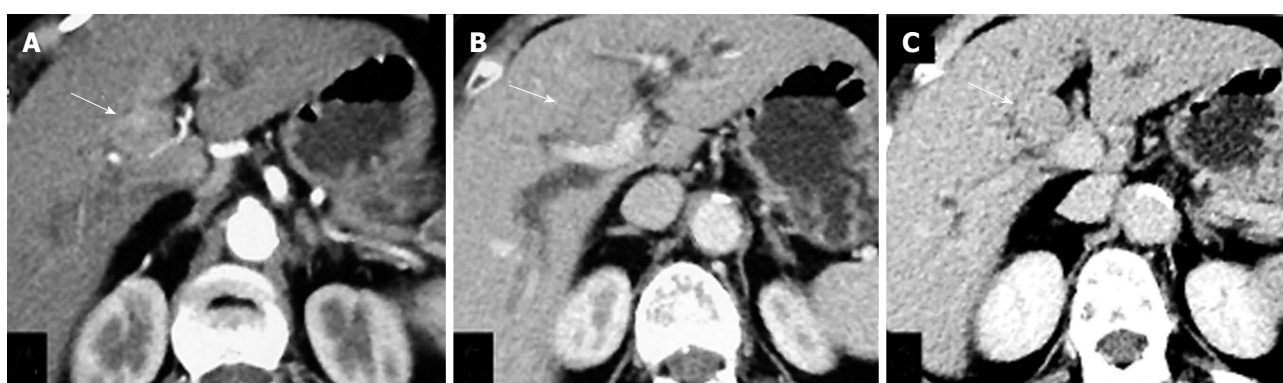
Axial contrast enhanced computed tomography scan in arterial (A), venous (B) and delayed (C) phases showing mild enhancement of the lesion (arrow) in arterial phase with persistence of enhancement in venous and delayed phases suggesting scirrhus nature of the lesion.
